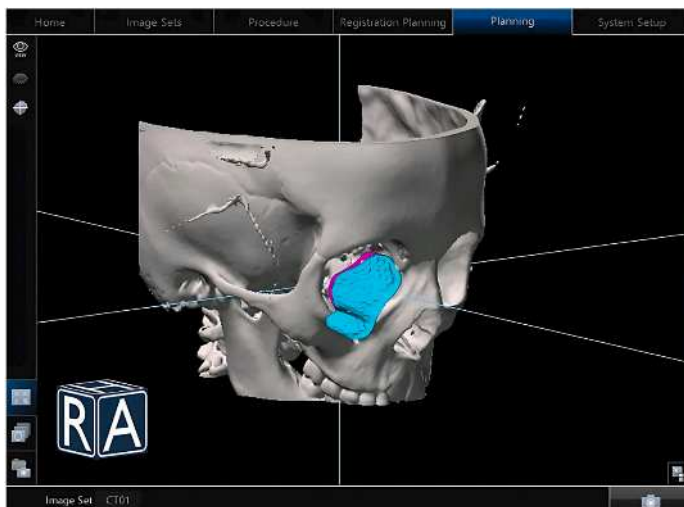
Superimposition of the achieved implant position from the postoperative CT image (blue) onto the preoperative position (pink), to evaluate accuracy of implant placement.
